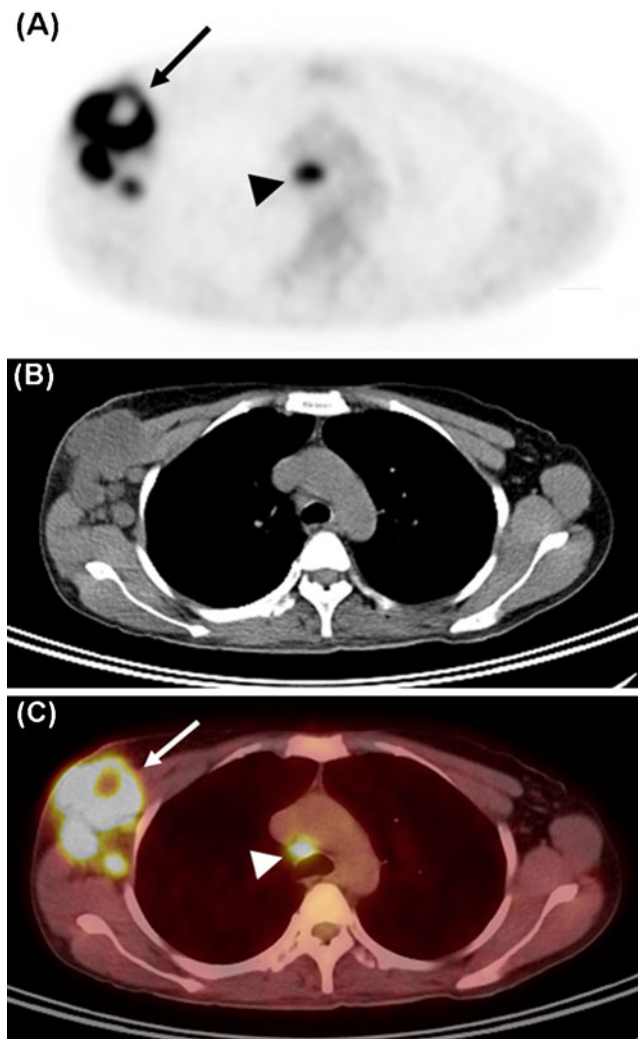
Transaxial ^{18}F -FDG PET (a), CT (b) and fused ^{18}F -FDG PET/CT (c) images of the right axillary nodal lesions. Multiple lymph nodes with intense ^{18}F -FDG uptake (maximum SUV of 8.8) are seen in the right axilla (arrow in a and c), which were diagnosed with tuberculous lymphadenitis. Moreover, a lymph node with intense ^{18}F -FDG uptake (maximum SUV of 5.0) is seen in the right lower paratracheal area of the mediastinum (arrowhead in a and c)
